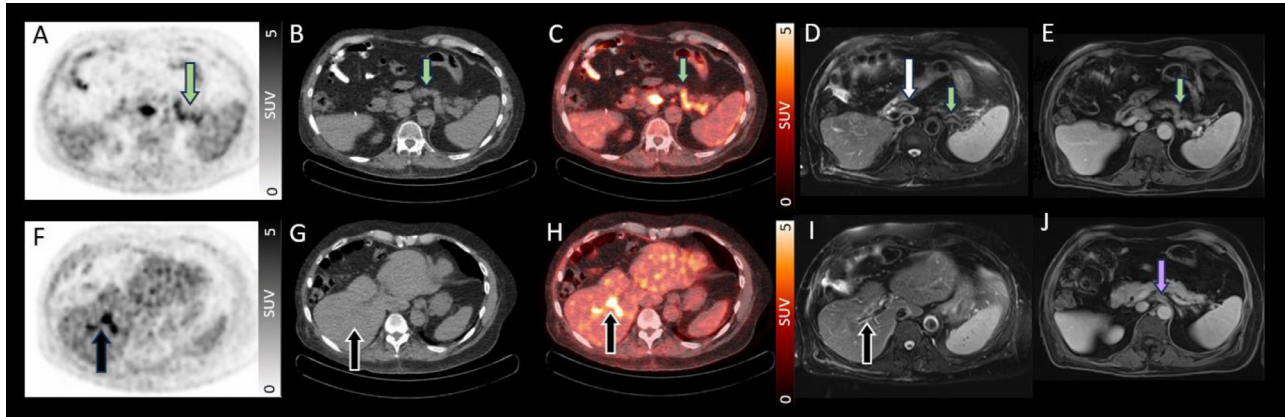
A 76-year-old man with malignant pleural mesothelioma on pembrolizumab underwent restaging FDG-PET/CT (A and F: PET only; B and G: CT only; C and H: fused PET/CT). FDG-PET/CT showed uptake along the splenic artery (panel A and C, green arrow, SUV_{max} of 5.7) and right hepatic artery (panel F and H, black arrow, SUV_{max} of 9.8) suspicious for vasculitis. Follow-up MRI (D and I: T2-weighted fat saturated MRI) for further characterization demonstrated mildly T2-hyperintense, thickened walls of the common hepatic (panel D, white arrow), splenic artery (panel D, green arrow) and right hepatic artery (panel I, black arrow). This MRI (E and J: T1-weighted post contrast-enhanced MRI [delayed phase]) also showed enhancement and wall thickening of the splenic artery (panel E, green arrow) and celiac artery (panel J, purple arrow), overall suggestive of medium-vessel vasculitis.
